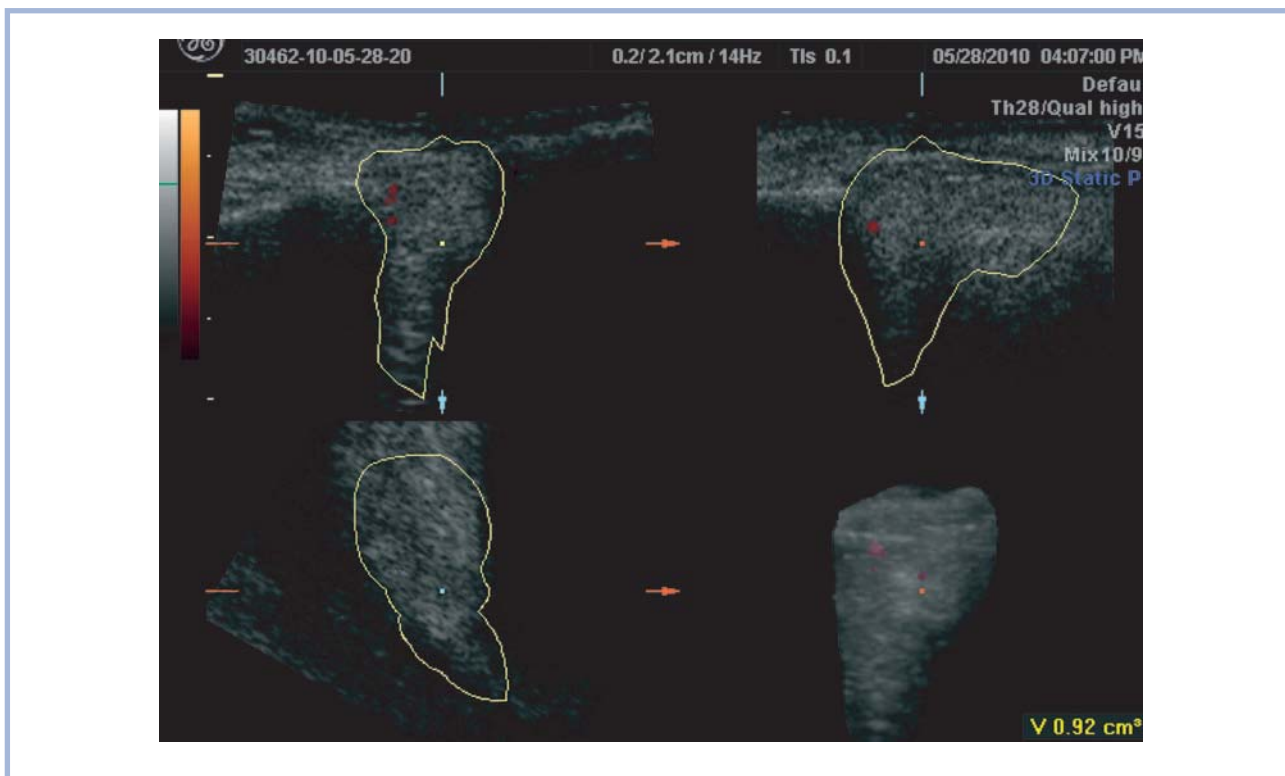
Multiplanar 3D ultrasonic analysis of a lacrimal gland in sarcoidosis. Pseudoedematous form of changes.
